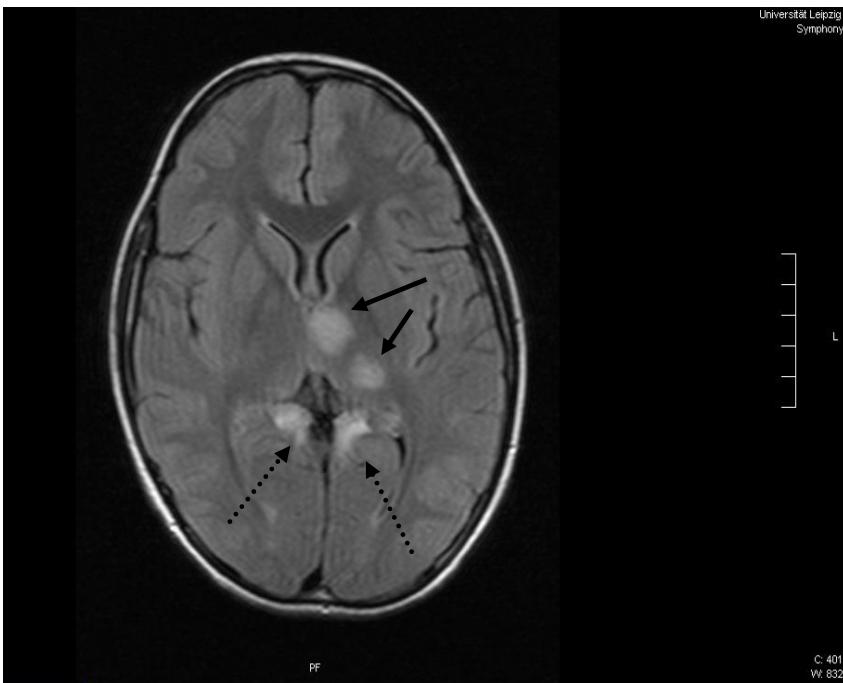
Cranial magnetic resonance imaging (16 days after therapy start) showing hyperdense areas in the occipital area (a/b; solid arrow) consistent with infarction in the distribution of the left posterior cerebral artery in a 2-year-old child with new onset of type 1 diabetes.
